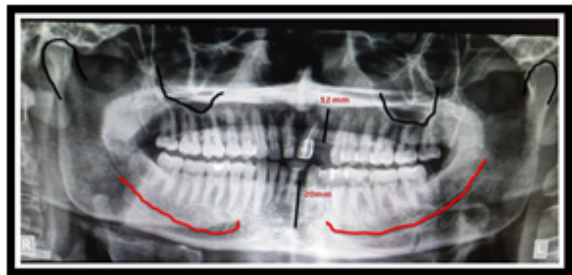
Orthopantomograph(OPG)
